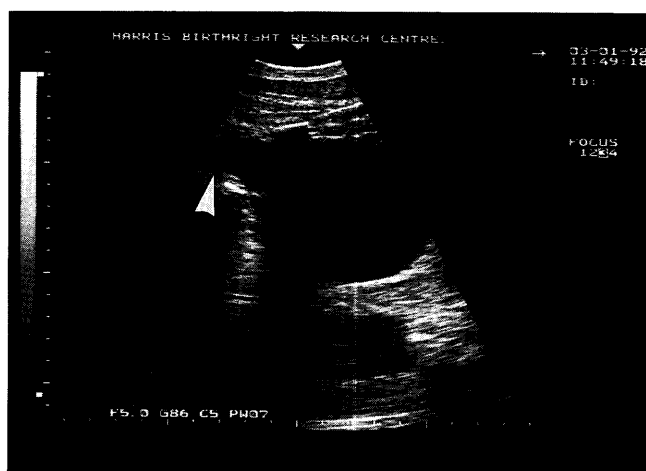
Ultrasound image of the lower abdomen in a female fetus showing a cyst with characteristic funnelling (arrow) arising from the pelvis
